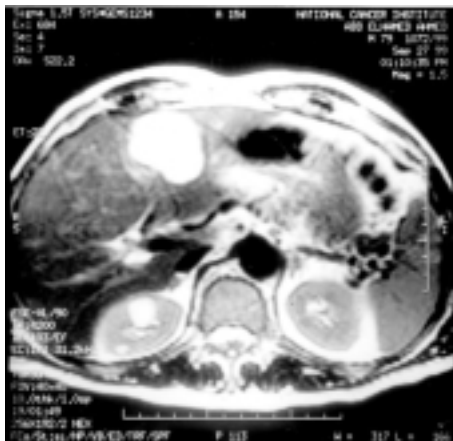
Axial T2-weighted spin-echo image confirming the cystic nature of the lesion.
